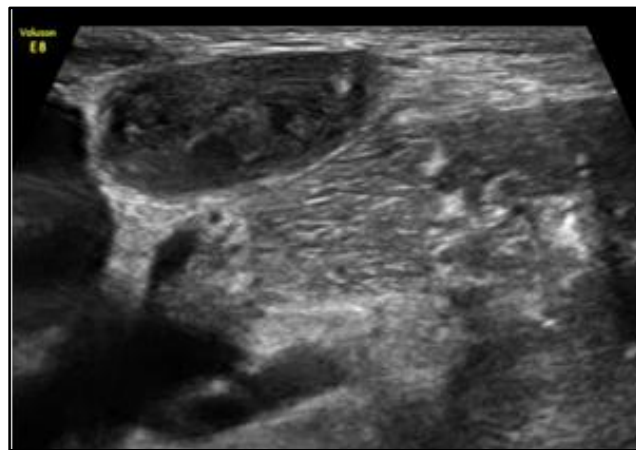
Transverse sonogram of level V cervical lymph node in a 20-year-old man, B-mode on left shows score of 7, Elastography on left shows pattern 1 (score 2) benign lymph node.
